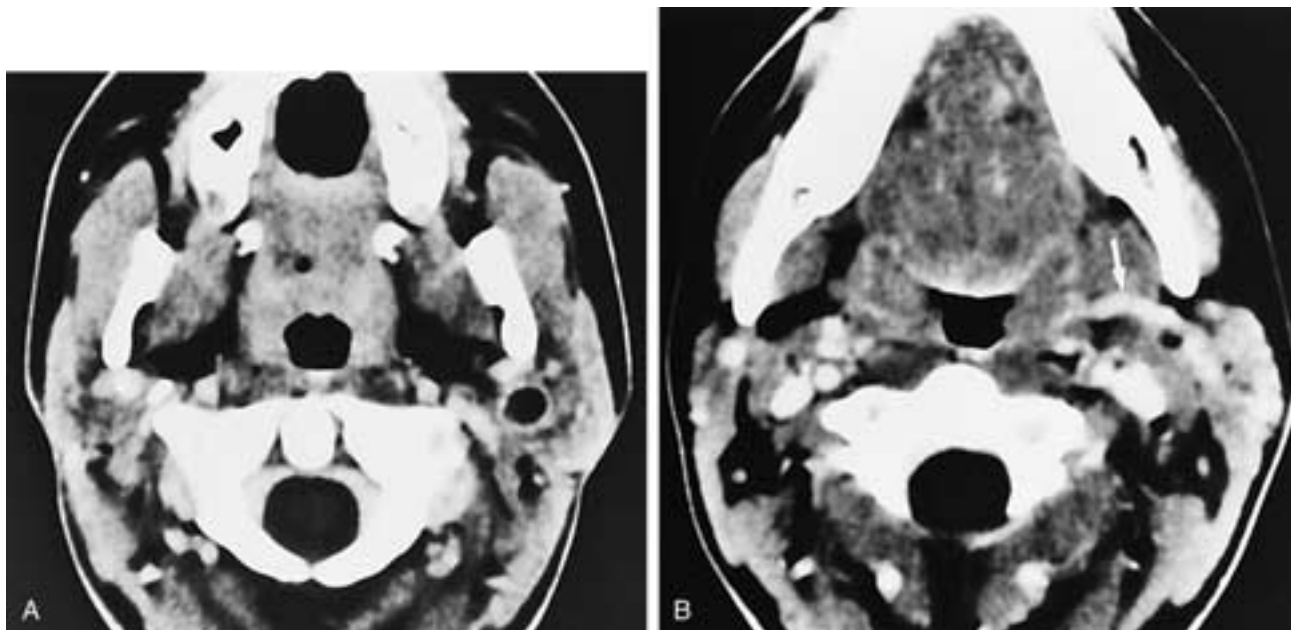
Axial contrast-enhanced CT scans through the parotid glands (A) and more caudally in the neck (B). There is a solitary smooth-walled cyst in the retromandibular portion of the left parotid gland. Extending from it is an enhancing sinus tract (*arrow*) that leads to the left palatine tonsil. This patient had an infected intraparotid second branchial cyst with an infected tract.
